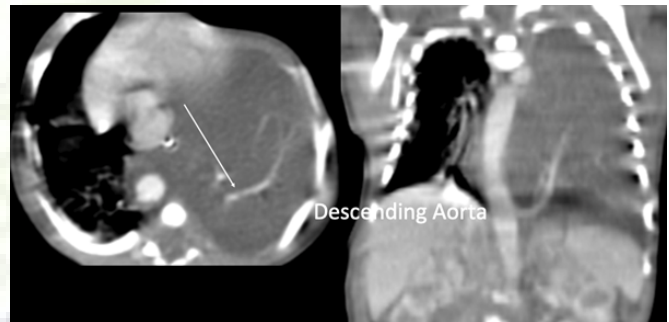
High resolution CT showing a feeder artery arising from the descending thoracic aorta.
